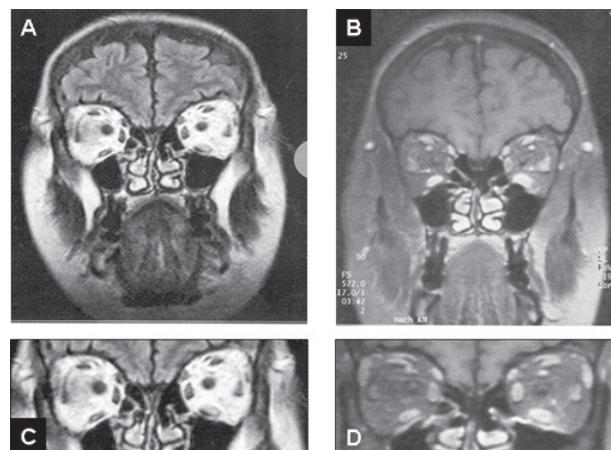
Coronal MRI (T2 left (A, C); contrast-enhanced T2 right (B, D, C, and D detail from A, B respectively) view of a patient with ocular myositis. Most prominent is the edema and swelling of the left inferior rectus muscle, although other eye muscles are also involved (A–D). This 48-year-old woman developed horizontal diplopia over a 5-day period, which was associated with dull retroorbital pain. She showed 5 mm of axial proptosis, chemosis, tenderness, and restricted ductions on the left side (SEOM patient). Treatment with corticosteroids was initiated, and after 10 weeks azathioprine was added, leading to complete remission of the symptoms within 7 month.
